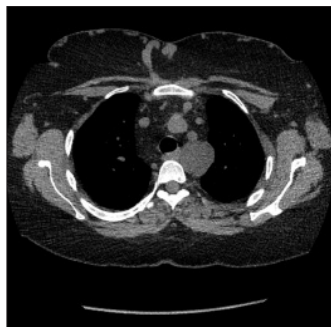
CT non-contrast study of upper mediastinum shows well defined slightly lobulated cystic structure with density 10Hu posterior to left subclavian artery.
